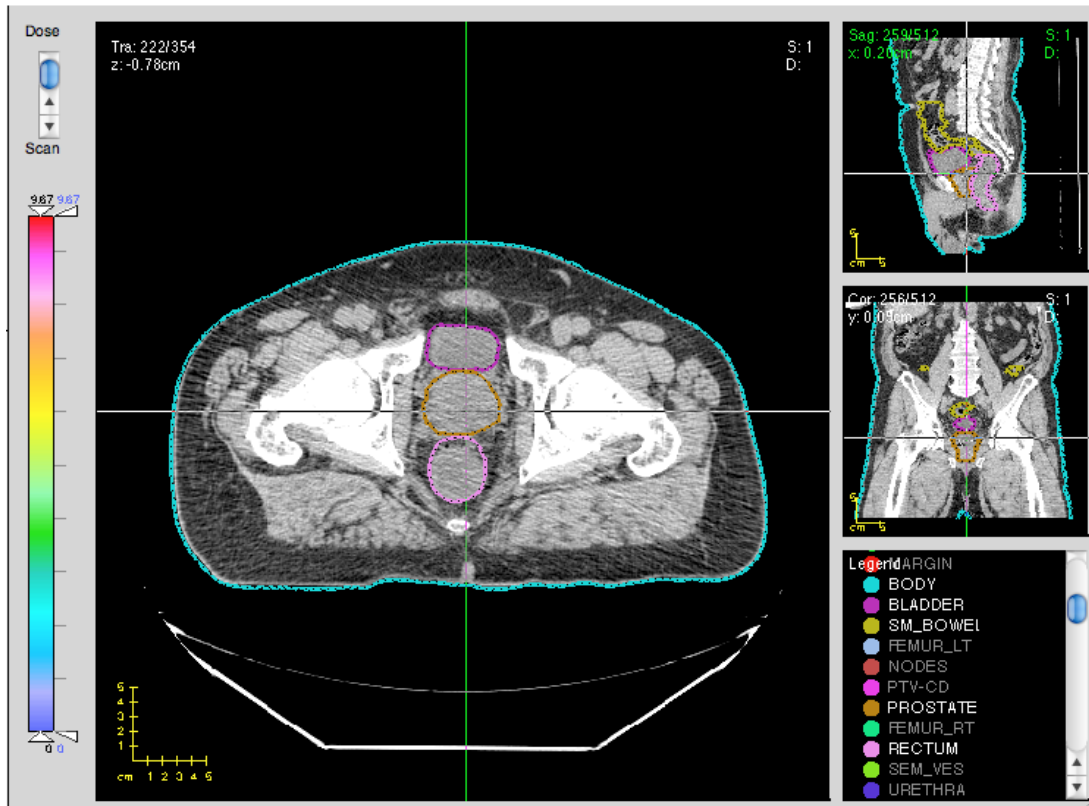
CT of the prostate patient case used in the experiment.
